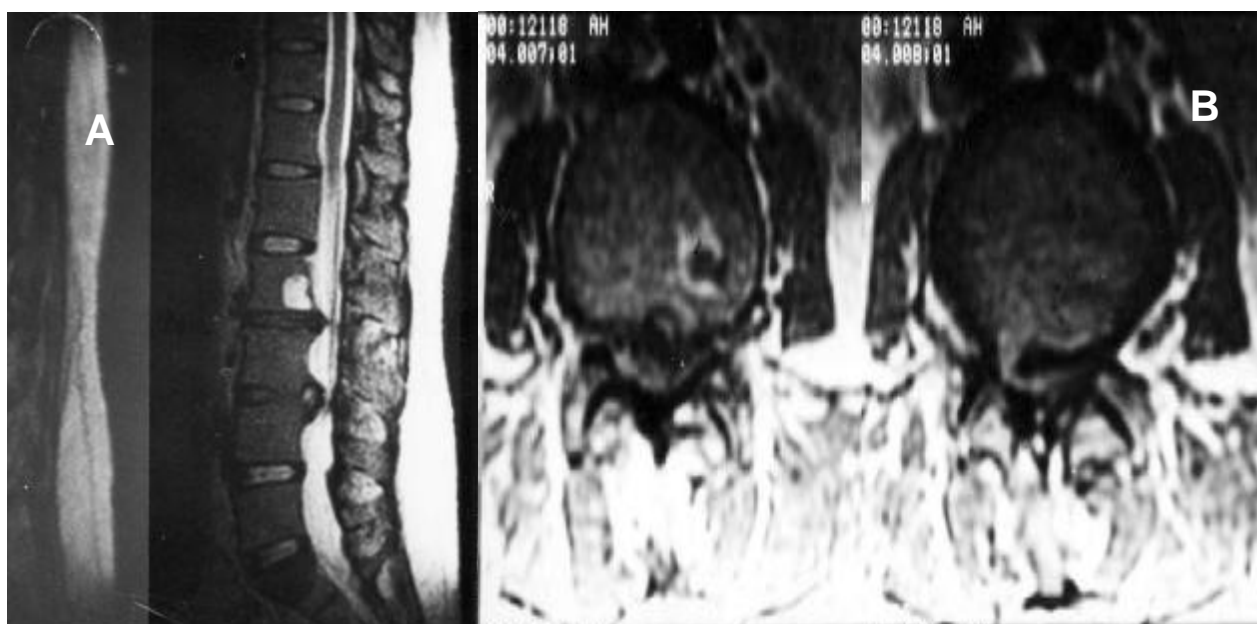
Magnetic resonance image of the lumbosacral spine midsagittal section. T₂-weighted image demonstrates disc herniation at L₂-L₃ and L₃-L₄, which obliterate the spinal canal (A). Axial view demonstrates spinal canal compromise at L₃-L₄ (B).
